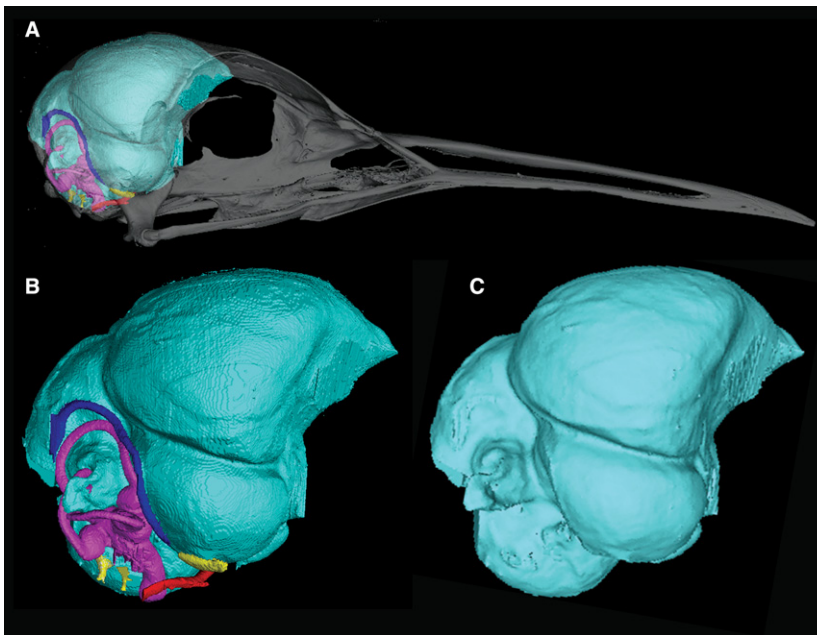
Three-dimensional (3D) renderings of the cranial endocast of *Eurypyga helias* constructed from CT data. (A) Cranial endocast of *E. helias* with transparent skull. (B) Cranial endocast of *E. helias* with cranial nerves (yellow), arteries (red), veins (blue), and inner ear (pink). (C) Cranial endocast of *E. helias* with inner ear, nerves, and vasculature digitally removed. A smoothing algorithm (Laplacian Smooth) has been applied to the rendering.
